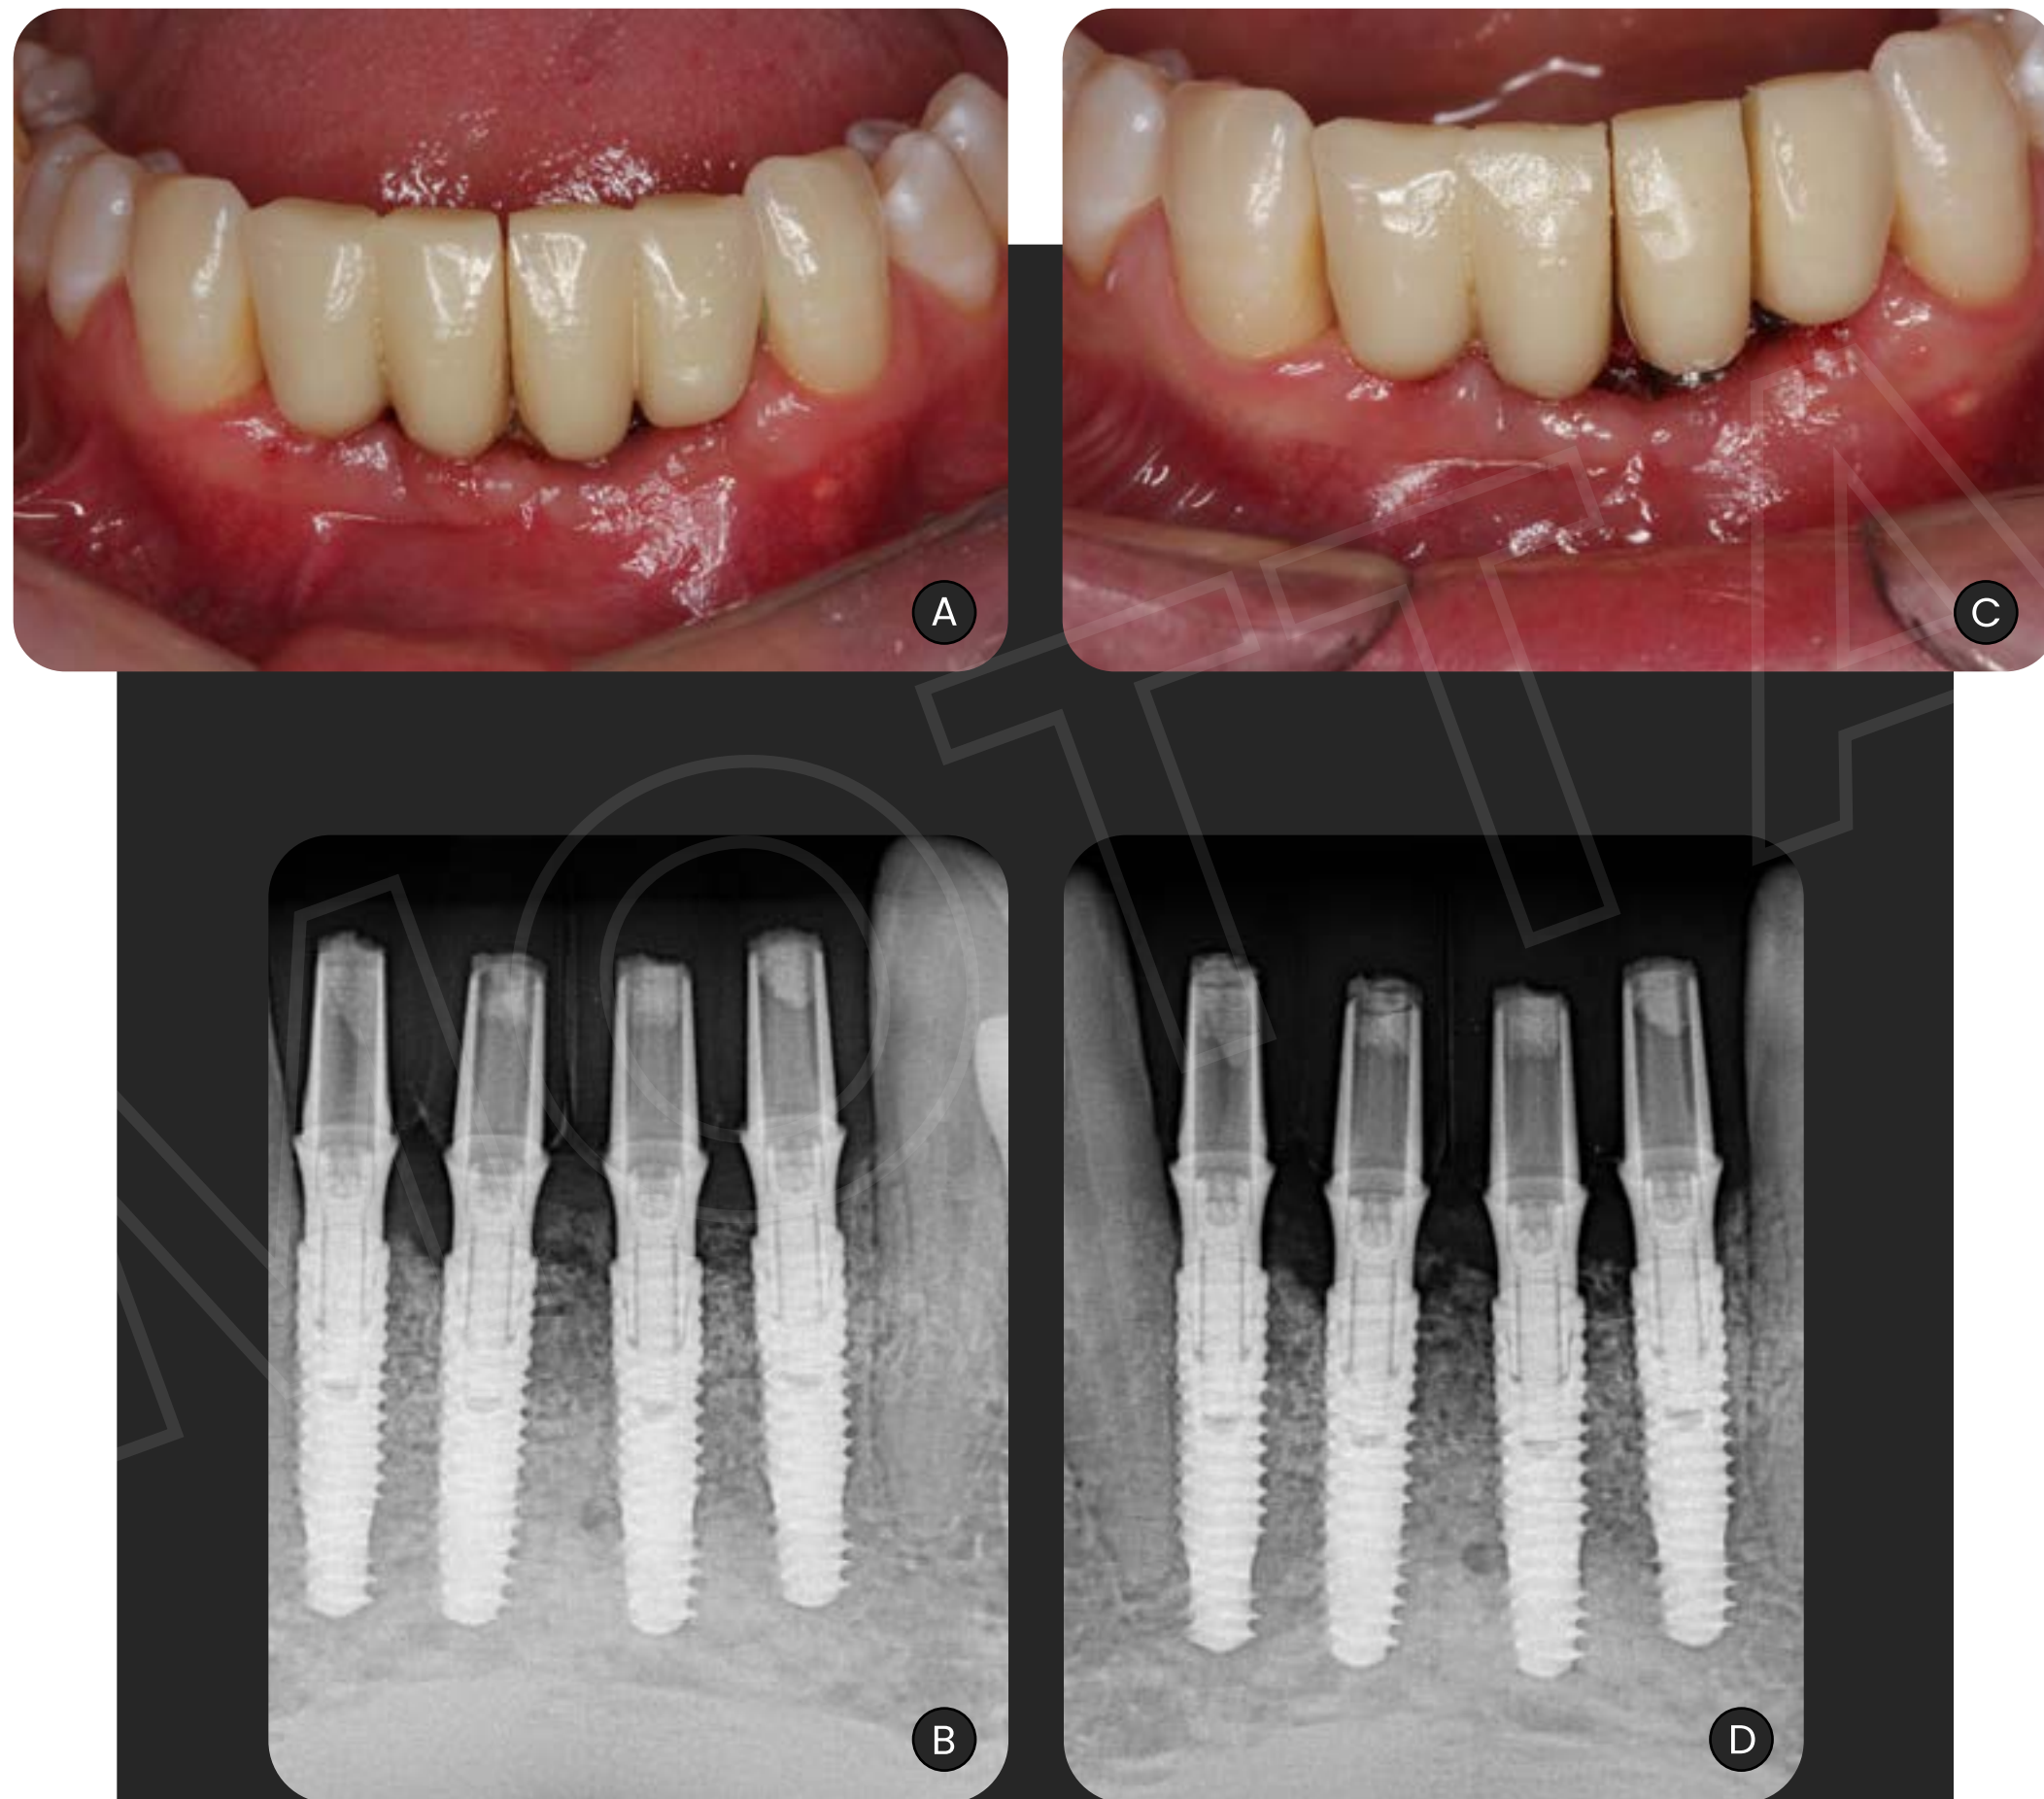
A and B: Clinical and radiographic follow-up for 1; C and D: and 2 months.
